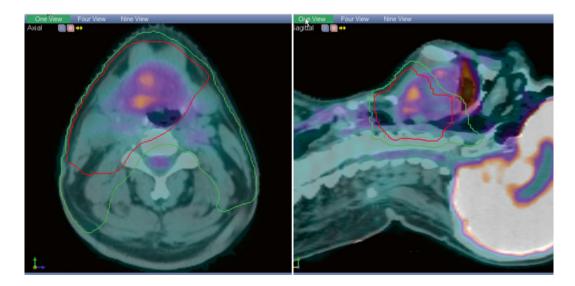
Demonstrates the response to chemoradiation therapy on the posttreatment PET-CT superimposed upon the RT planning scan [Courtesy of Jeff M. Michalski, MD]
